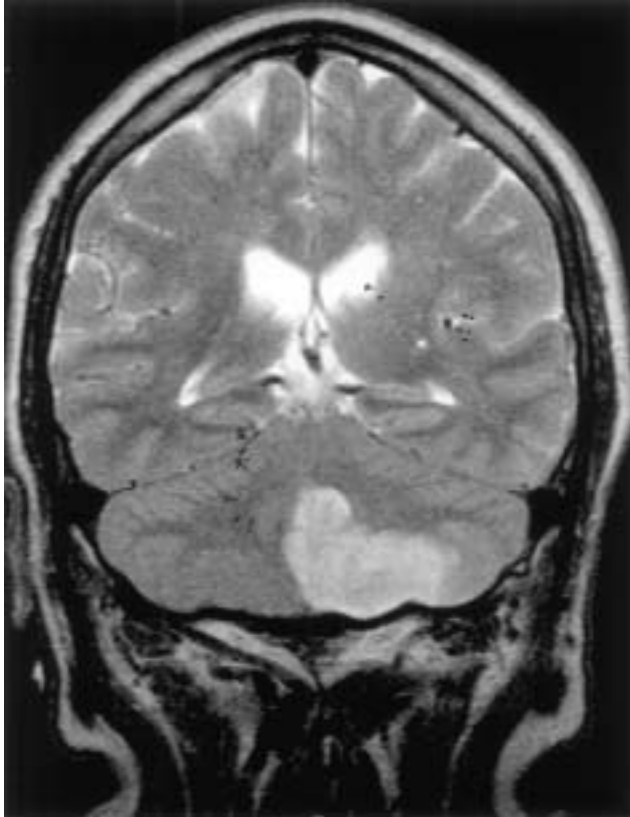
A 64-year-old man with high blood pressure, diabetes and a history of prior stroke acutely developed “dizziness,” slurred speech and inability to walk, with a tendency to fall consistently towards the left. A brain CT scan performed shortly after he was brought to the hospital was normal, but this MRI scan demonstrated a large area of stroke injury involving his left cerebellum.
